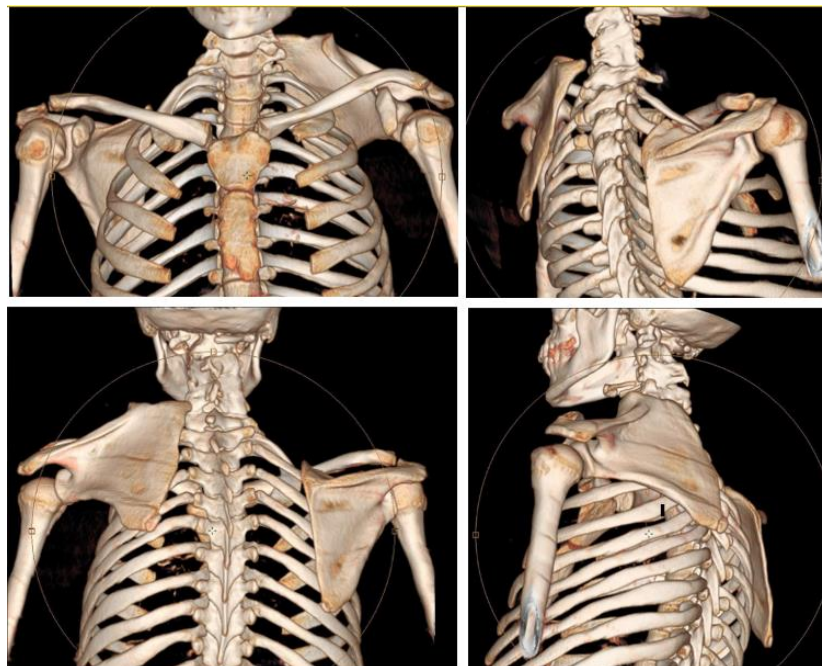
CT images in VR reconstruction showing a grade II Sprengel malformation according to the Rigault and Pouliquen classification, with no detectable omo-vertebral bone or fibrous or cartilaginous structure visible on ultrasound. There is an extensive vertebral block from C2 to C6, which explains the torticollis, as well as agenesis of the left hemi-arch of C1 and a dysmorphic appearance of the spinous processes of the fused cervical vertebrae
